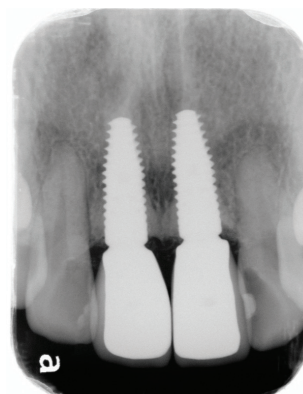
The periapical x-ray of definitive prosthesis
